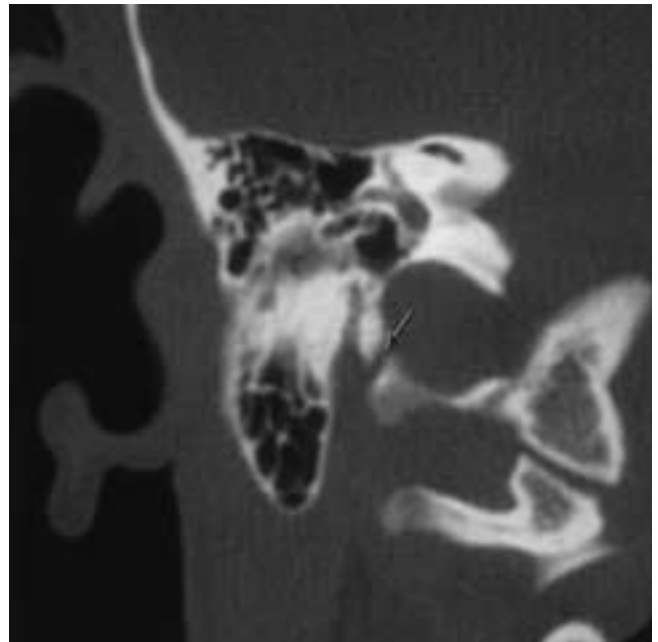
Pseudofracture, mastoid canaliculus. Coronal CT image of the right ear demonstrates the communication between the jugular foramen and the mastoid segment of the facial nerve canal (*arrow*). (From Swartz JD, Harnsberger HR. Imaging of the Temporal Bone, 3rd ed. New York: Thieme, 1998.)
